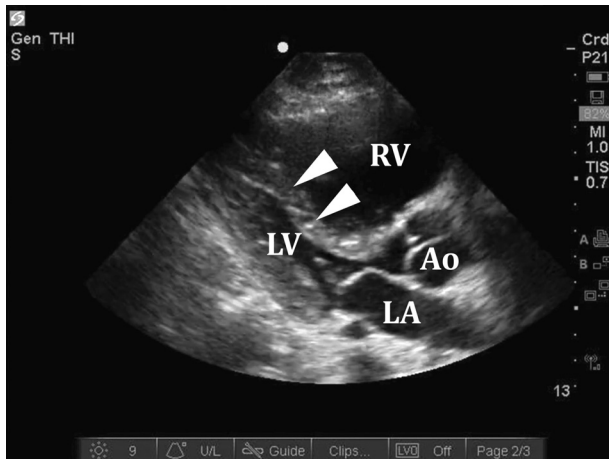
Parasternal long axis view of the heart with an enlarged RV causing septal bowing (arrowheads) into the LV. Left atrium (LA) and aortic outflow tract (Ao) also noted.
